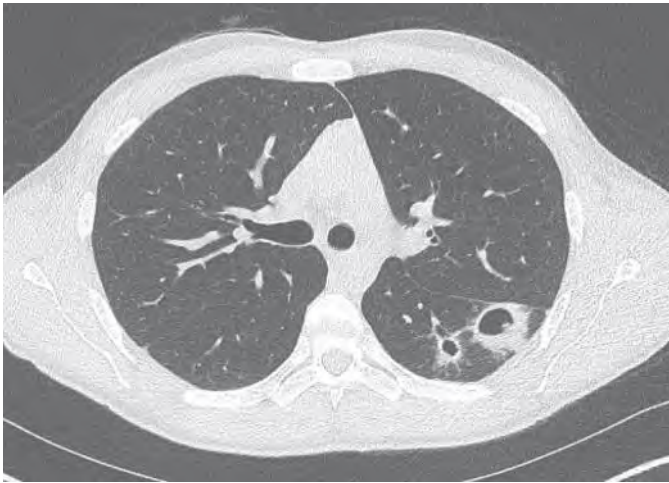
A 28-year-old man with a history of intravenous heroin and cocaine use presented with 5 days of pleuritic chest pain. At computed tomography of the chest, he was found to have 18 cavitary lung nodules. An axial image containing two of the largest lesions is shown. He was ultimately diagnosed with *Staphylococcus aureus* tricuspid valve endocarditis complicated by septic pulmonary emboli. (Courtesy Daniel Taupin, MD, NYU Langone Health.)
